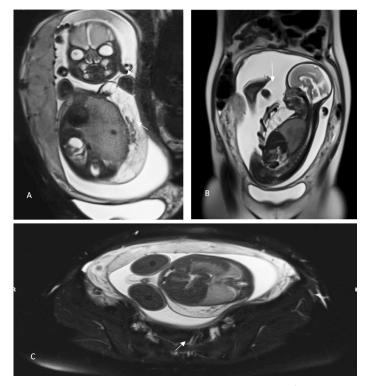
Fetal Magnetic Resonance Imaging (MRI – T2 images) at 27 weeks age of gestation. A & B. Axial view, T2-W hyperintense and T1-W isointense extensive subcutaneous mass (labeled with arrows) with internal flow voids within, involving the right thoracoabdominal region, primary consideration is a hemangioma. The diaphragm appears intact. C. Transverse view at the level of the fetal chest. Subcutaneous mass seen external to the lungs; no cystic lesion identified in the lungs. No intrathoracic, intra-abdominal or spinal axis involvement seen.
